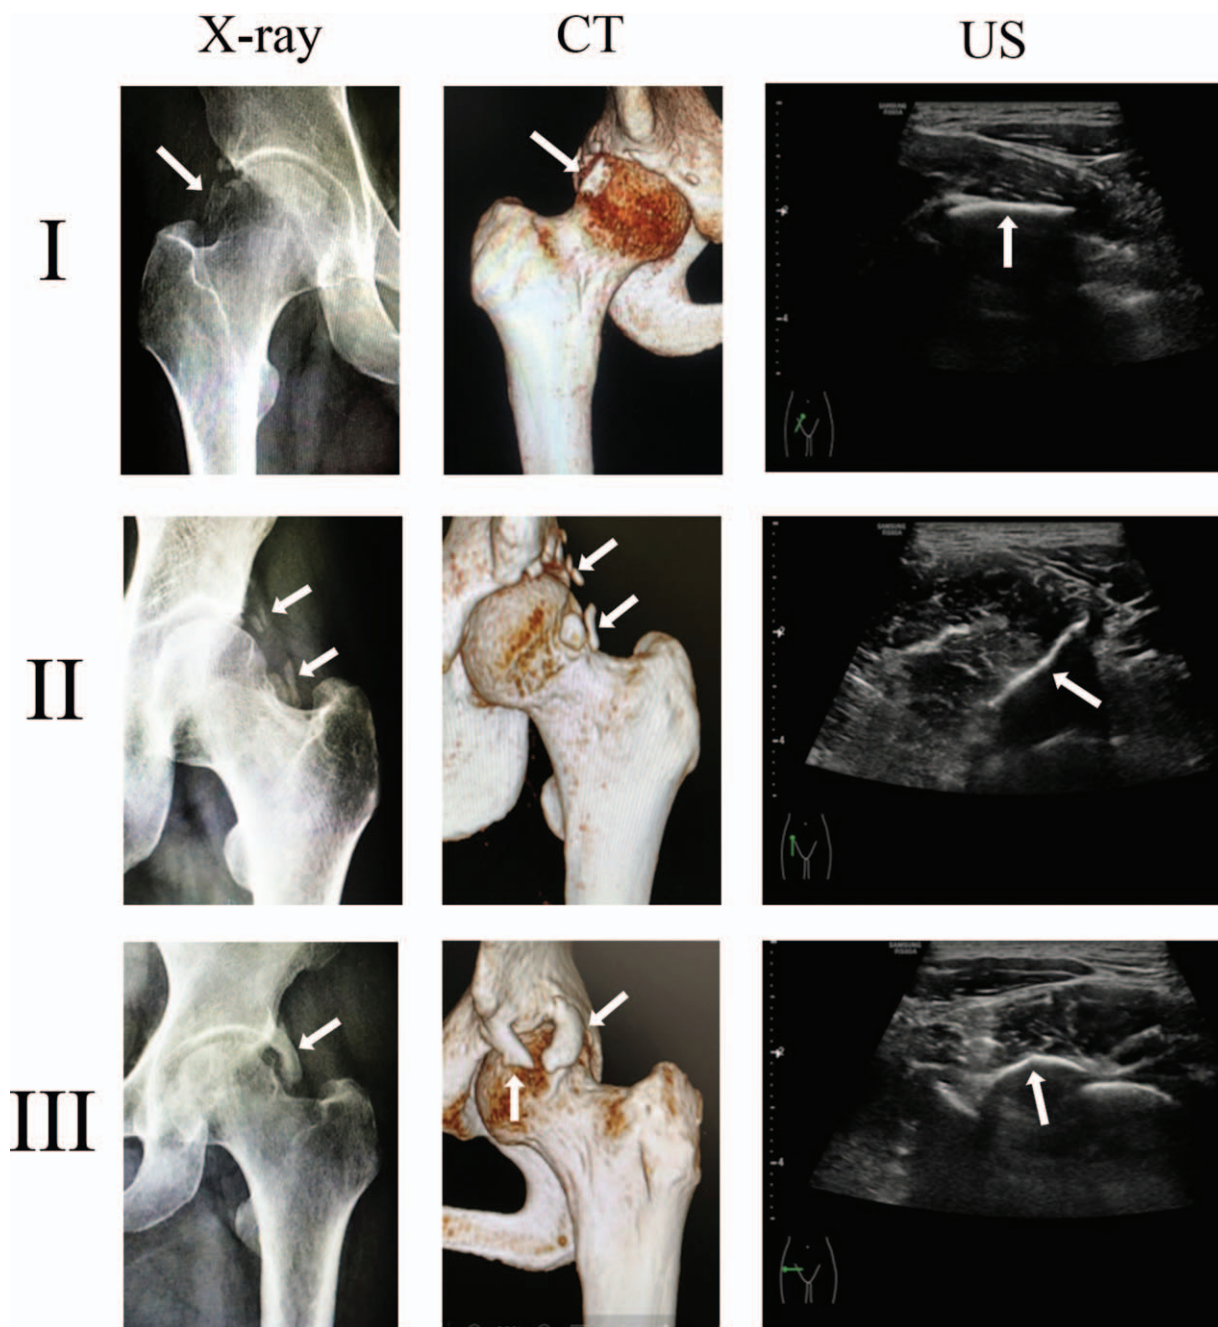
X-ray, CT and ultrasound of heterotopic ossification after hip arthroscopy in this study, showing heterotopic ossification stage I to III according to Brooker classification. White arrows show the position of heterotopic ossification. Isolated bony islands were observed in stage I, bone spurs from the pelvis or proximal end of the femur with more than 1 cm of space between opposing surfaces were observed in stage II, and bone spurs from the pelvis or proximal end of the femur with less than 1 cm of space between opposing surfaces were observed in stage III. The heterotopic ossification is identified by highly echogenic areas with attenuation or complete disappearance of the acoustic signal distal to these areas in ultrasound. CT: Computed tomography; US: Ultrasound.
